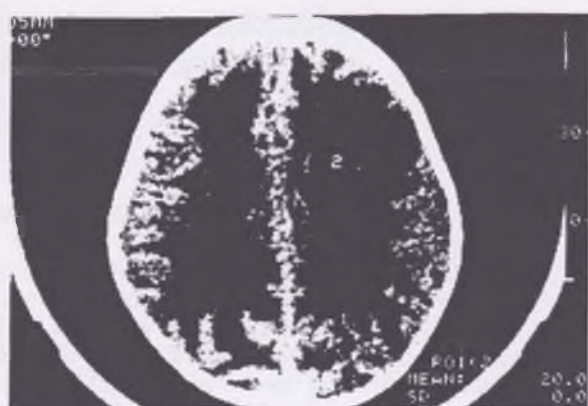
Case 2 (OLT 131). The CT scan shows small gas collections in the posterior parietal region (1); anteriorly (2), a round hypodense area surrounded by hyperdense pad is evident.
